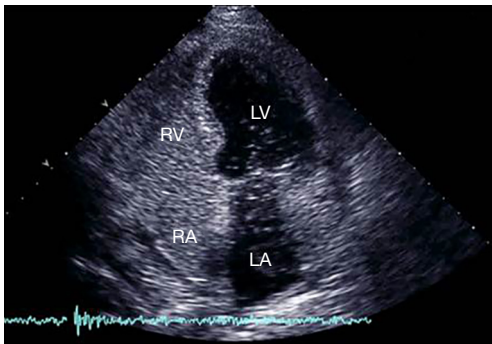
Visualization of an intracardiac shunt through a patent foramen ovale with agitated saline in a patient ventilated for an ARDS with transthoracic echocardiography. ARDS, acute respiratory distress syndrome; LV, left ventricle; LA, left atrium; RV, right ventricle; RA, right atrium.
